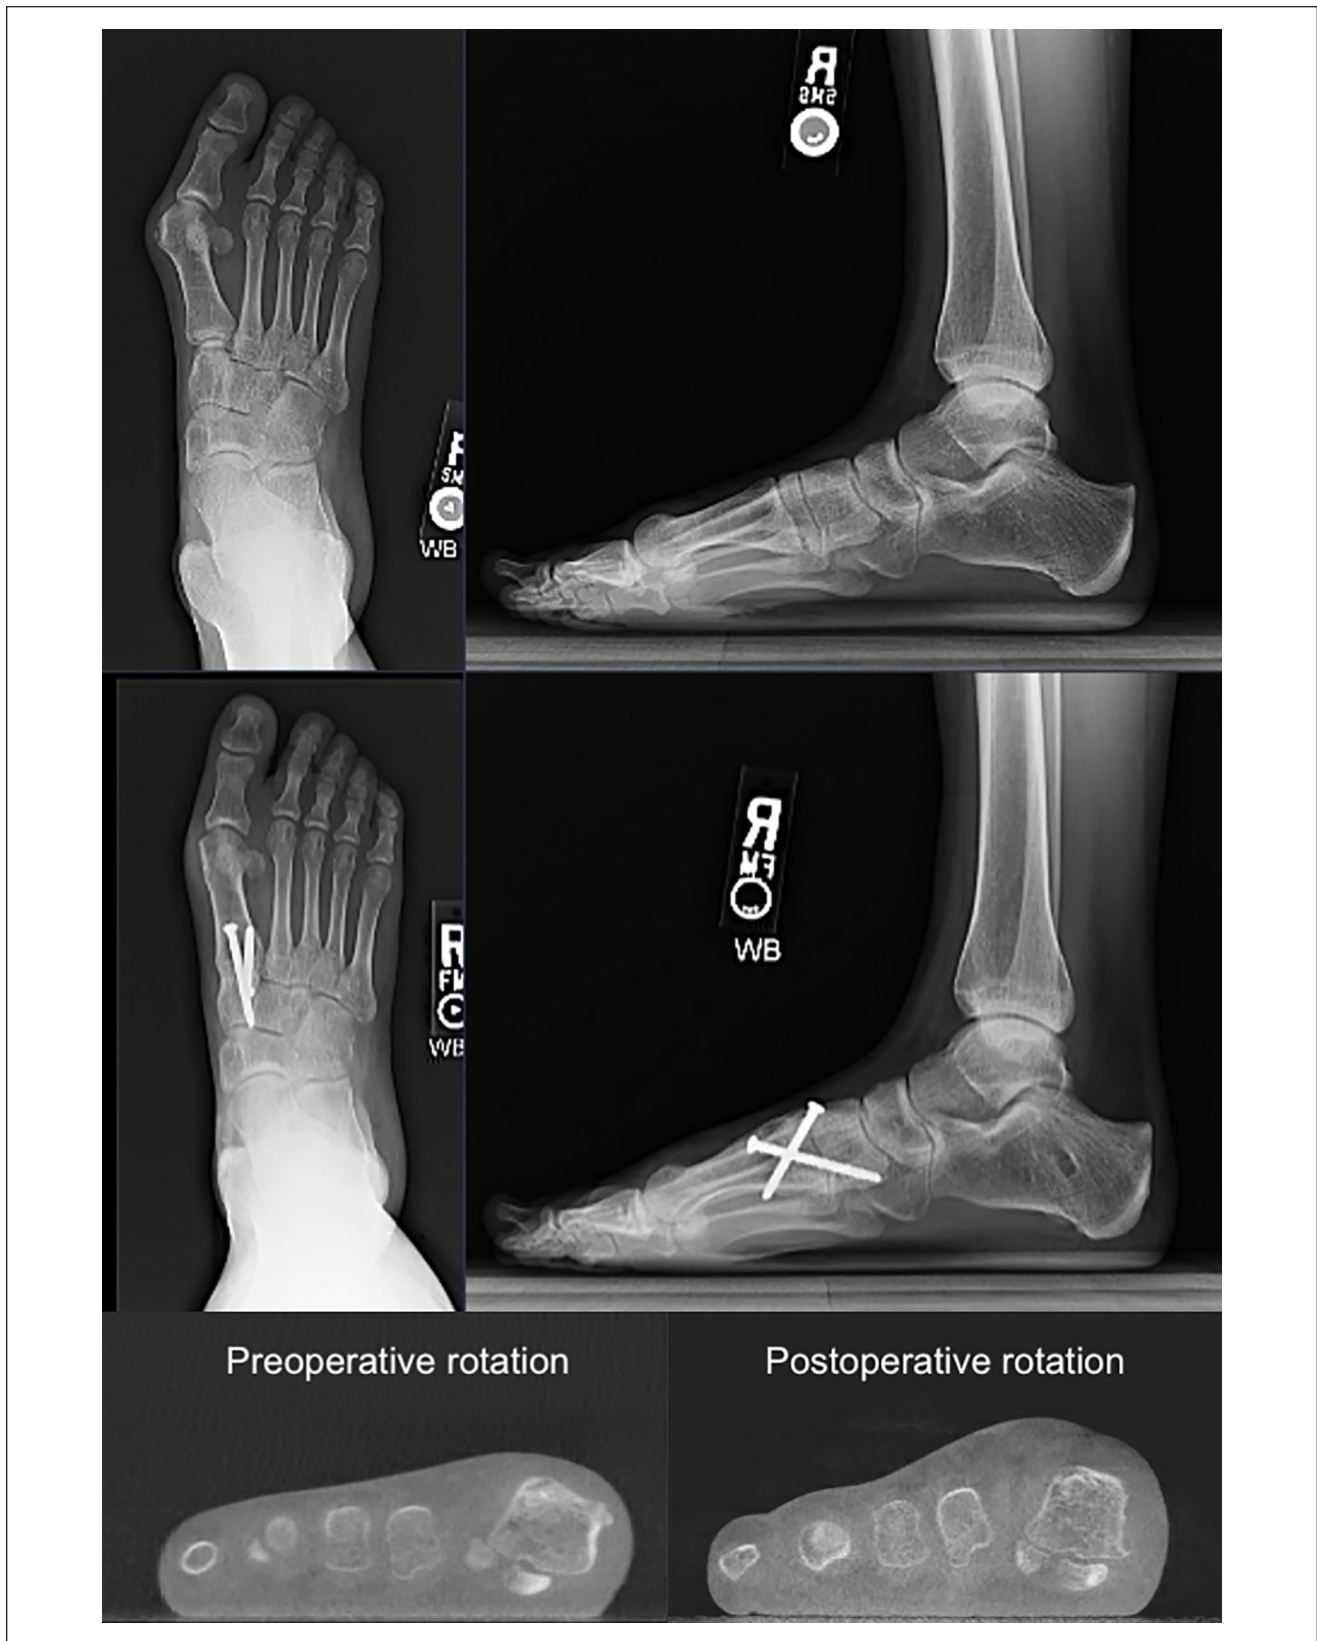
Pre- and postoperative radiographs for case example of hallux valgus fixed with cross-screws. Bottom: First metatarsal rotation evaluated on weightbearing CT pre- and postoperatively.
